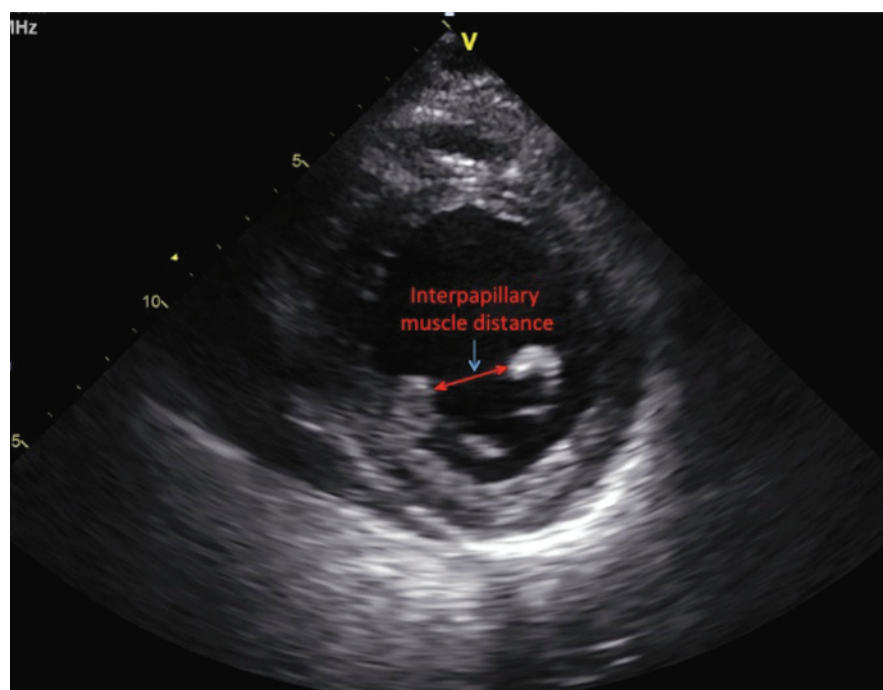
Parasternal short-axis view at the level of the papillary muscles at end-systole on transthoracic echocardiogram.
